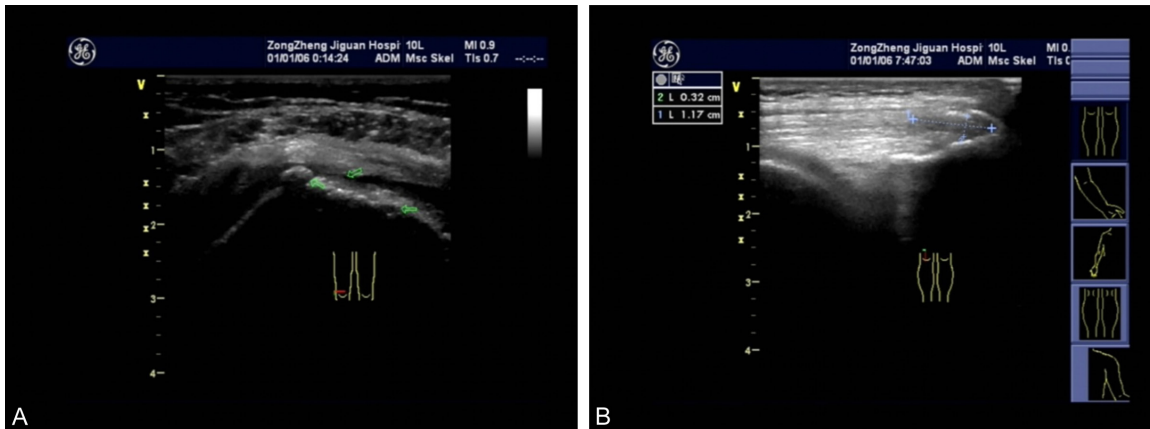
Representative high-frequency ultrasound images of crystal deposition in the knee joint. A. Gouty arthritis, demonstrating hyperechoic deposits distributed along the synovial/articular surface (arrows). B. Calcific tendinitis, demonstrating a localized intratendinous hyperechoic calcific lesion with imaging measurement.
